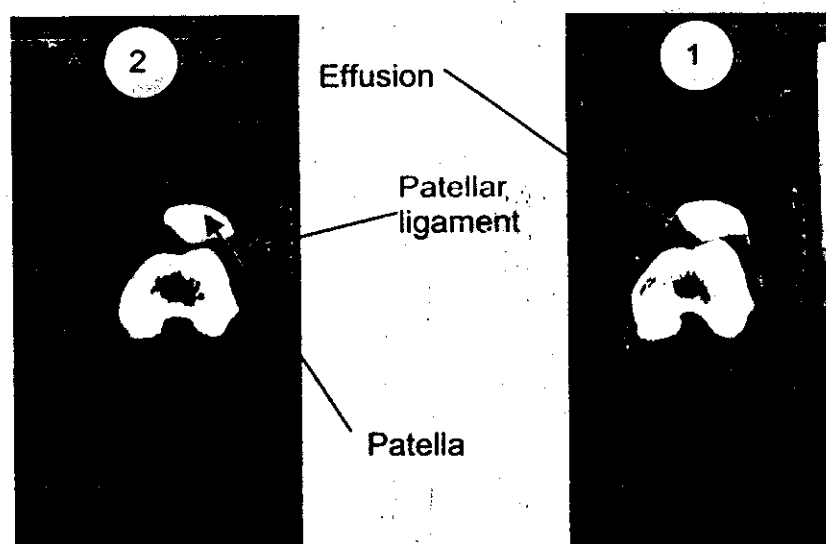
CT scanning of knee joint before and after conventional therapy
